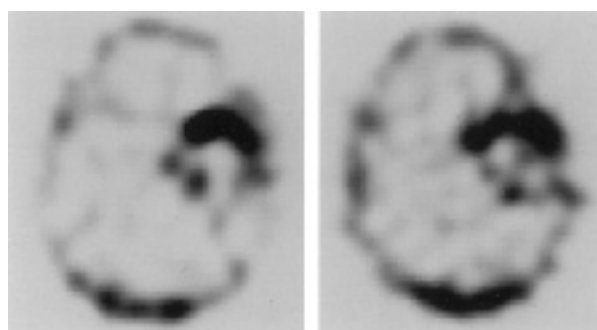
Tl-201 early (*left image*) and late (*right image*) brain SPECT in a 71-year-old woman with metastatic lesions from lung carcinoma, 6.0 cm in diameter. The early uptake ratio (ER), the late uptake ratio (LR) and the ratio of LR to ER were 2.89, 2.39 and 0.83, respectively.
